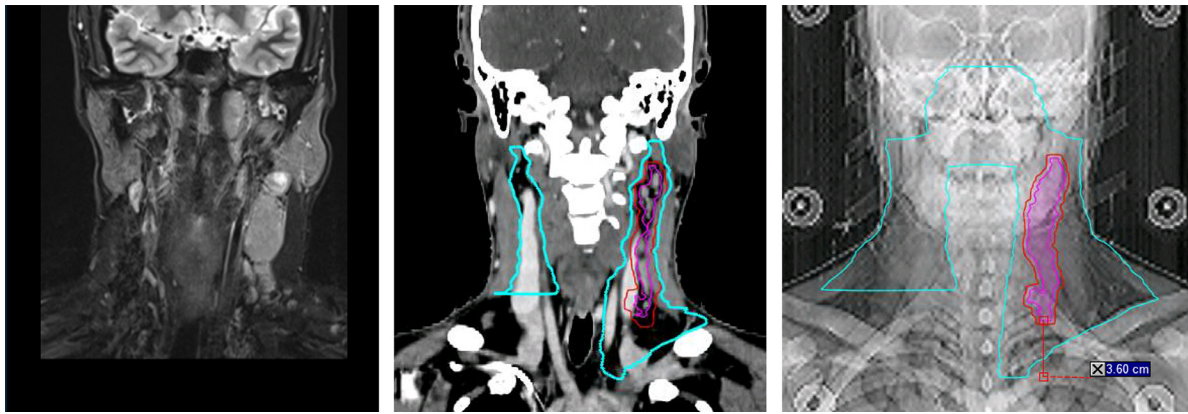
Delineation of nodal clinical target volume (CTVn). Left column: The preinduction magnetic resonance imaging (MRI) depicts positive lymph nodes (LN) with advanced extranodal extension (ENE) infiltrating the sternocleidomastoid muscle of the right neck (yellow arrows) and contralateral LN without ENE in the left neck. Right column: The postinduction computed tomography (CT) planning images show delineation in accordance with International Guideline-2024 (IG-2024). For LN with advanced ENE in the right neck: nodal gross tumor volume (GTVn) (purple line) is based on the preinduction extent, including the infiltrated muscle, and CTVn<sub>70</sub> (red line) equals GTVn plus an 8-mm margin. For LN without ENE in the left neck: GTVn is based on the postinduction extent, and CTVn<sub>70</sub> equals GTVn plus a 3-mm (acceptable range 0-5 mm). The delineation of CTVn<sub>50</sub> (blue line) is based on the anatomical boundary of the corresponding nodal levels, encompassing CTVn<sub>70</sub>.
